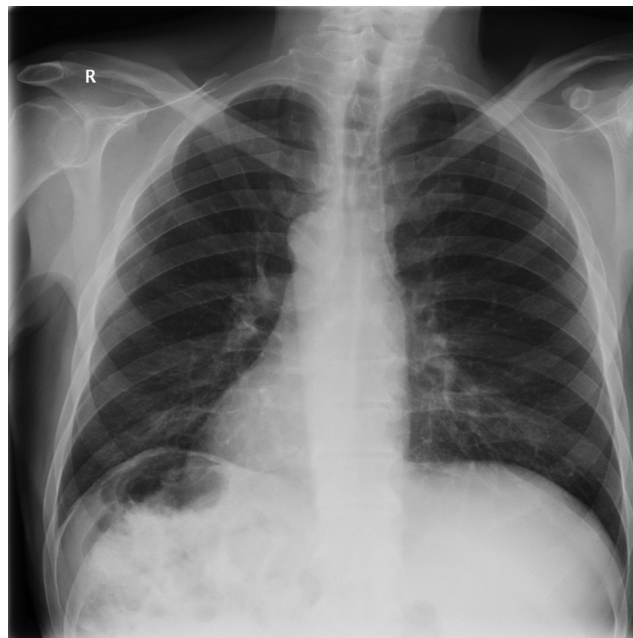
Chest X-ray showed dextrocardia and right-sided gastric air bubble.
